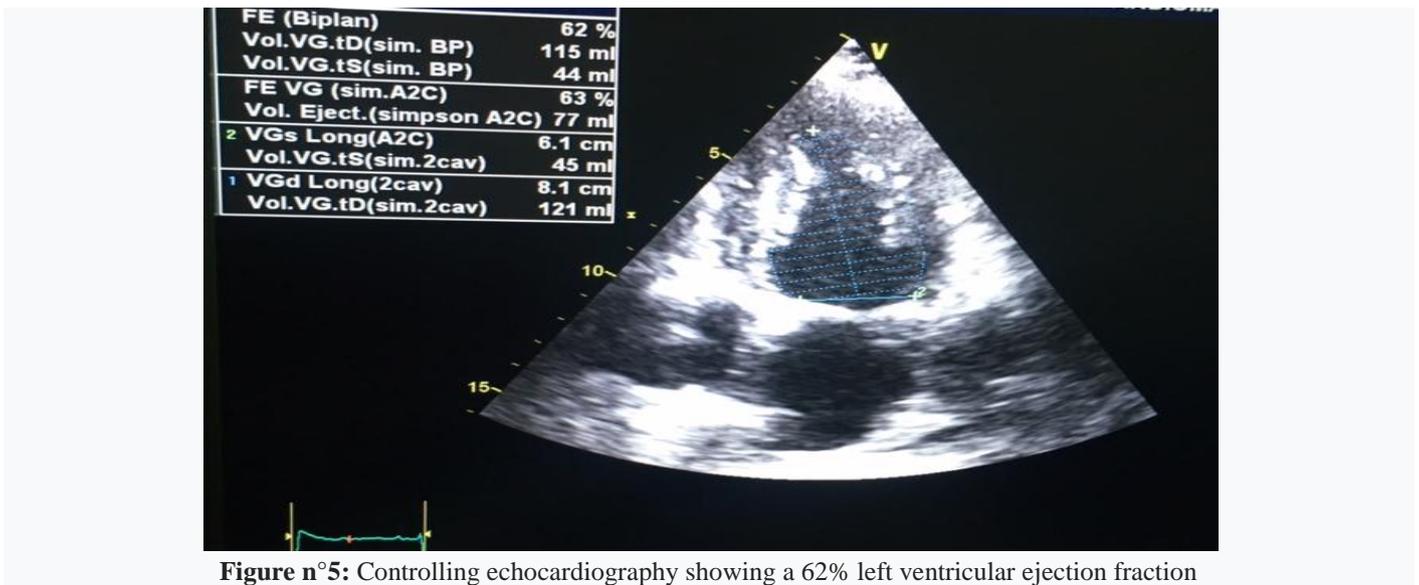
Controlling echocardiography showing a 62% left ventricular ejection fraction
